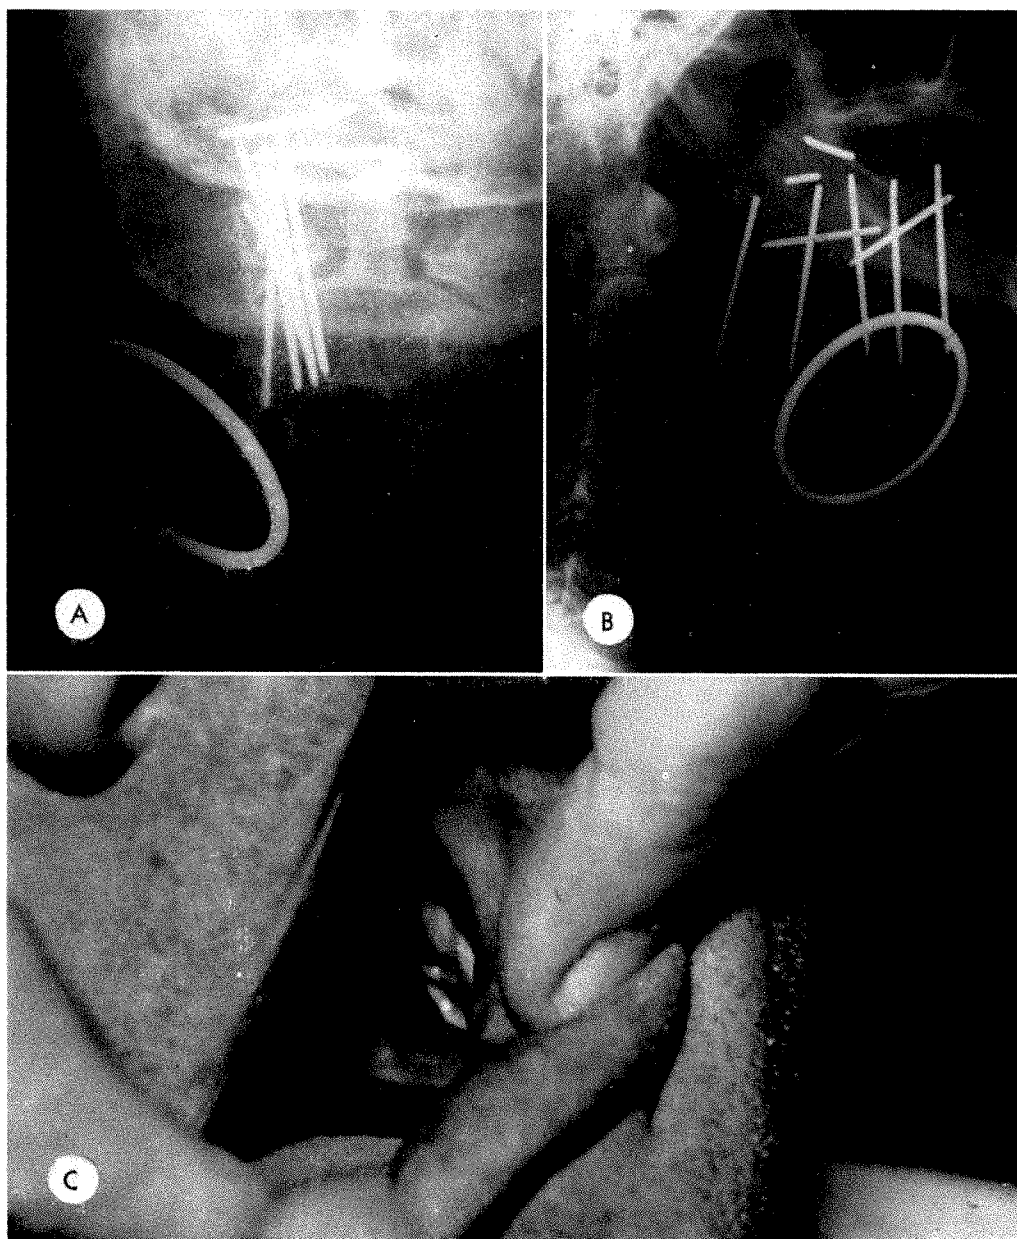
L.R. 45 W M. *Squamous cell carcinoma of the most posterior portion of the medial aspect of the left lower gum, attached to bone without invasion of it.* A combined technique of 220 kv. roentgen rays, single field, and single plane radium implant was used.
